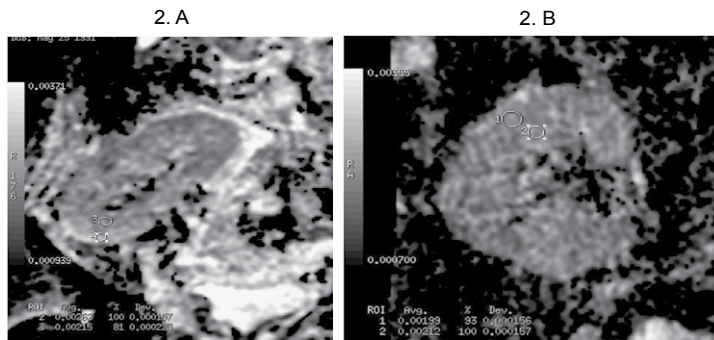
Diffusion weighted MRI of kidney transplant with Apparent Diffusion Coefficient (ADC) of the cortex is less than medulla in normal kidney transplant (a), while in kidney transplant dysfunction the ADC is still high in cortex than medulla but both are of low value than the normal kidney (ADC of cortex and medulla is $2.15 \times 10^{-3}/s^2$ and $2.5 \times 10^{-3}/s^2$ in normal kidney, and $1.99 \times 10^{-3}/s^2$ and $2.12 \times 10^{-3}/s^2$ in kidney dysfunction).
